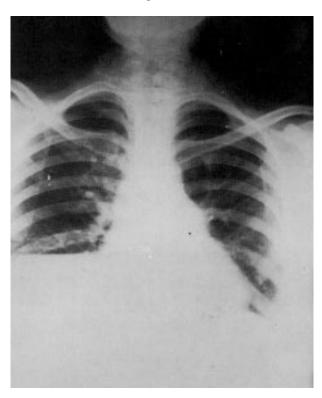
Chest roentgenogram. Dilated pulmonary arteries and clear lungs. The elevation of the right hemidiaphragm Points out a marked hepatomegaly due to multiple hydatid cysts as shown at autopsy.
